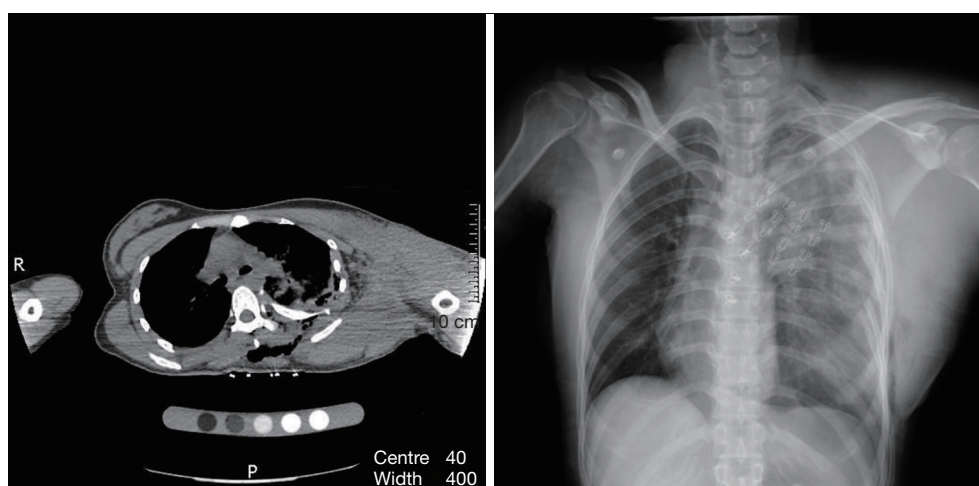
It showed the severe rib fracture on the left side of the patient with displacement of fractured ends on CT. The fractured ribs were close to the thoracic aorta, while there was no a large amount of bleeding in the chest and obvious thoracic aortic injury.
